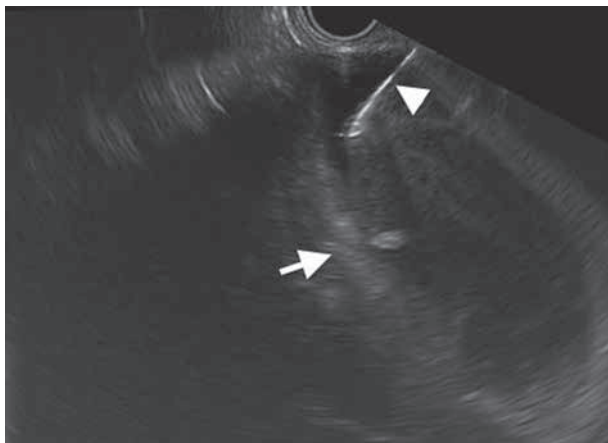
Endoscopic ultrasound revealed multiple septa (arrow). The arrowhead shows the tip of 22 Gauge needle inside the cyst.
